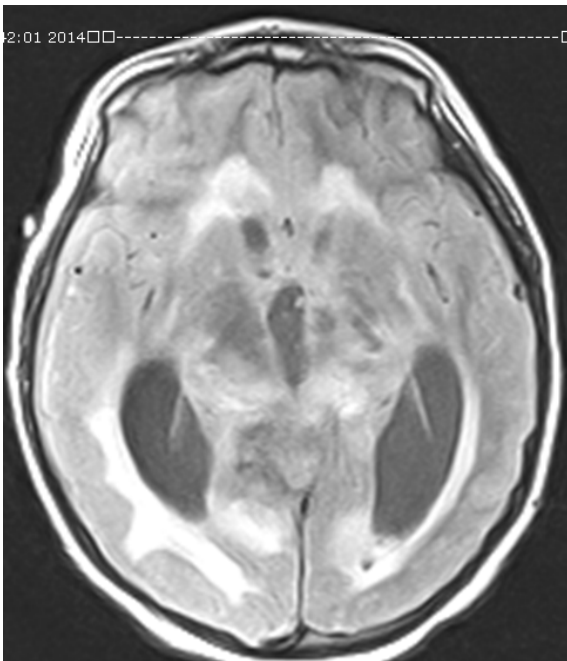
MRI image showing common parenchymal intracranial calcification, hydrocephalus, increase in brain edema and a hyperdense appearance in favor of temporal region involvement.
